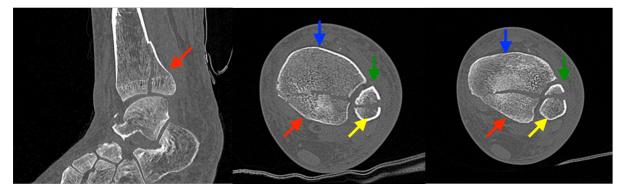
Computed tomographic scan in medial view of the left ankle (preoperative). It confirmed the posterior wedge fracture of the posterior malleolus, which was slightly displaced (red arrow). The fibula is not visible. Figure 4. Computed tomographic scan in axial view of the left ankle (preoperative). On the left side the tibia is shown (blue arrow) and on the right the fibula (green arrow). This image confirmed the fracture of the posterior malleolus (red arrow) and validated the lateral malleolus fracture (yellow arrow). Figure 5. Computed tomographic scan in axial view of the left ankle (preoperative). It showed the tibia (blue arrow) and the fibula (green arrow). Similar to Figure 1, this image underlined the posterior malleolus fracture (red arrow) and supported the theory of the lateral malleolus fracture (yellow arrow).
